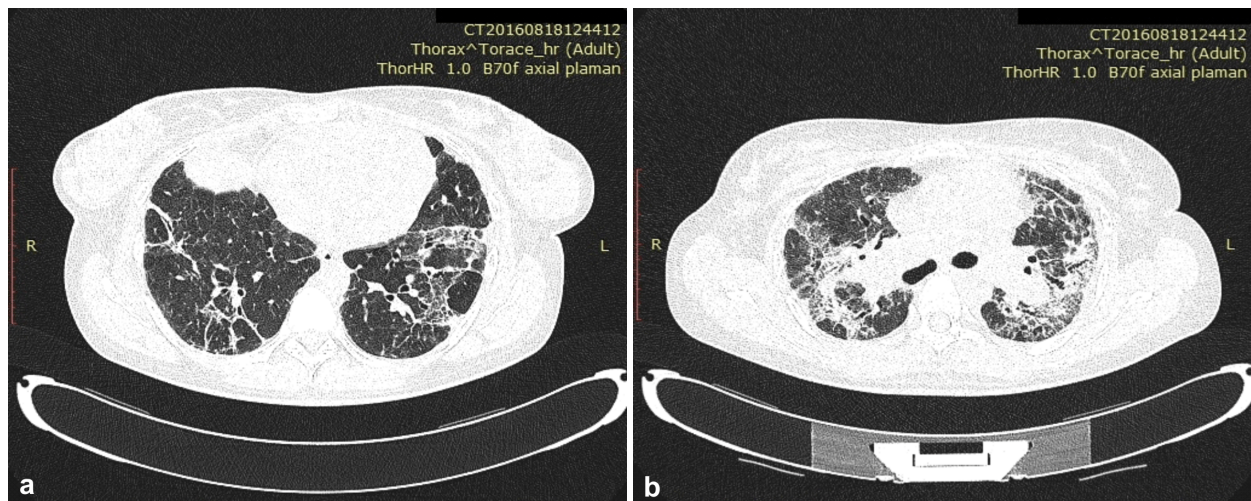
(a) Chest HRCT showing significant pulmonary fibrosis “in thick lines” with centrilobular, interlobular and subpleural localization in both lungs; (b) Traction bronchiectasis in the right upper lobe and left lung and ground-glass opacities in upper lobes.
